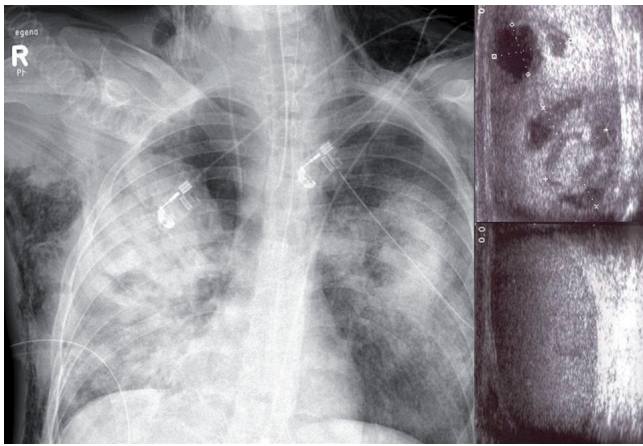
Radio- and ultrasound diagnostics. *Left*: Skin emphysema, pneumonia in the upper and middle lobe; massive bleeding into the parenchyma. *Top right*: Testicular tumour with inhomogeneous echogenicity, partly hyperechogenic to some extent hypoechogenic. *Bottom right*: Three months later after treatment. Homogeneous echogenicity with a slight hypoechogenic pattern in the former suspected tumour region.
